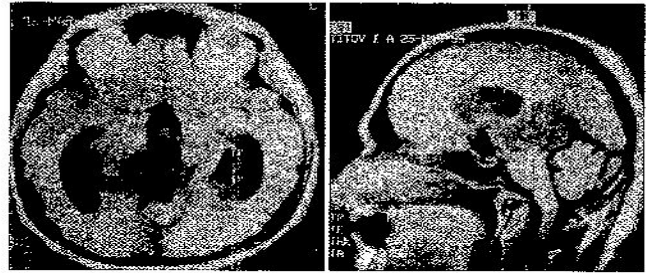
Case 6. Preoperative T₁-weighted MR images demonstrating inferoposterior displacement of the deep venous system.
